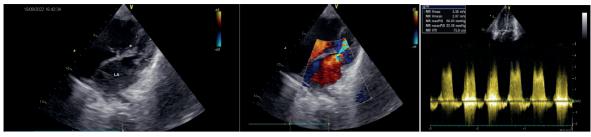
Echocardiographic evaluation.
